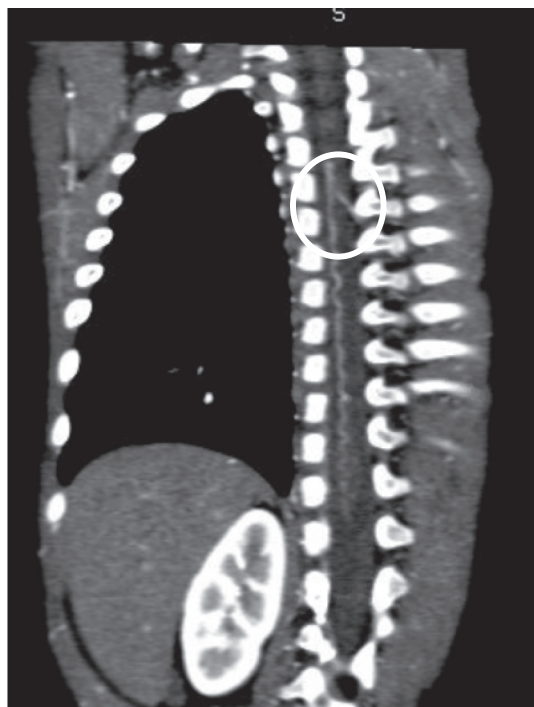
CT evaluation of the position of the artery of Adamkiewicz. In this coronal plane, the artery of Adamkiewicz connects with the anterior spinal artery between the T5 and T6 thoracic vertebrae.
